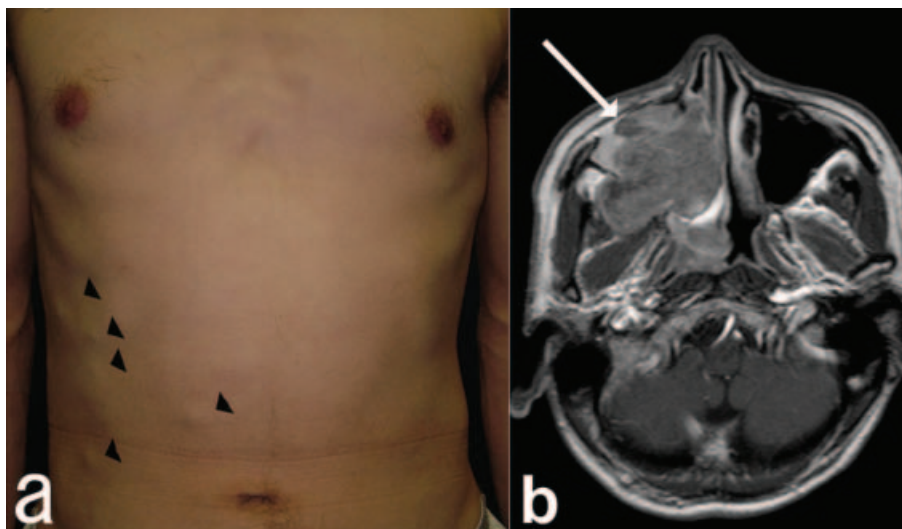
(a) Multiple subcutaneous nodules (arrowheads) ranging from 0.5 to 1.5 cm in diameter on the trunk. (b) Magnetic resonance imaging of the sinuses demonstrated a large mass (arrow) occupying the right maxillary sinus that had invaded the nasal cavity.
